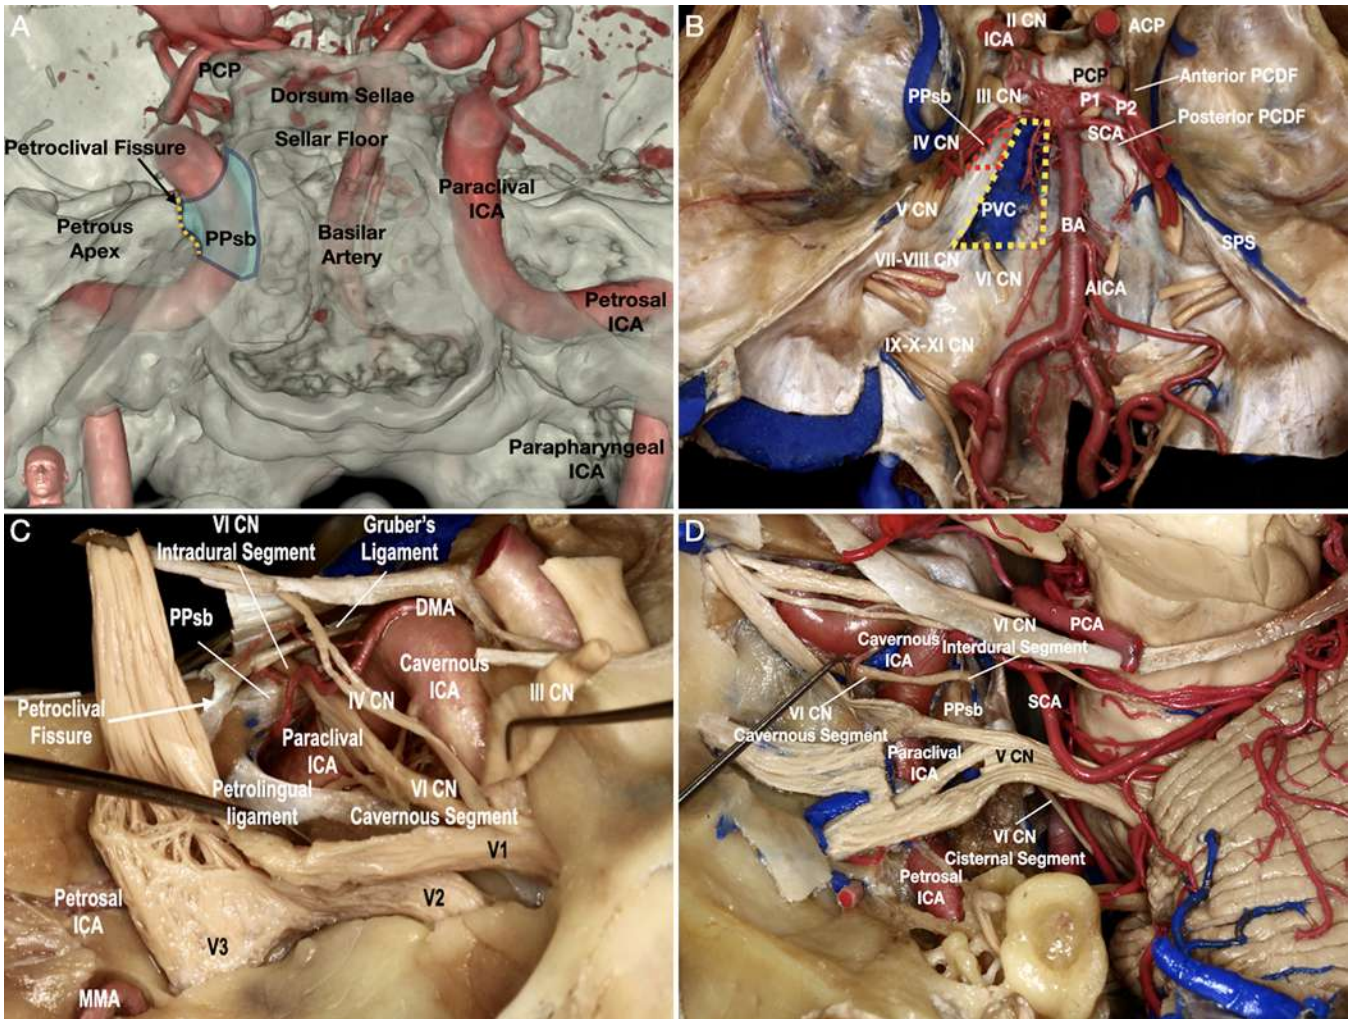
Neurovascular relationships. A: Anteroposterior view of a skull base CT angiography reconstruction. The petrosal process of the sphenoid bone (PPsb) (blue shading) is posterior to the paraclival internal carotid artery (ICA) and demarks the transition between the extracavernous and intracavernous segments. The PCF (yellow dotted line) is lateral to the ICA. The 3D reconstruction was created from CT angiography using Surgical Theater software (Surgical Theater, LLC). B: The brain has been removed, preserving the cranial nerves (CNs) and vascular structures. The inner dural layer has been partially opened on the left side to show CN VI running inside the petroclival venous confluence (PVC) (yellow dotted trapezoid) but outside the IPS. The PPsb location is highlighted (red dotted triangle). C: Lateral view of the lateral wall of the right CS. The PPSb is shown posterior to the ICA and inferior to CN VI. The course of CN VI can be observed inside the CS. CN V is retracted inferiorly to show the PLL, which together with the PPSb forms the inferior limit of the CS. D: Overview of the course of CN VI and the carotid artery. The petrosal bone has been drilled to show the prepontine cistern and the cisternal segment of CN VI, as well as the petrosal segment of the ICA. The PPSb marks the transition between the interdural and cavernous segments of CN VI and the transition between the paraclival and the cavernous ICA. ACP = anterior clinoid process; AICA = anterior inferior cerebellar artery; BA = basilar artery; DMA = dorsal meningeal artery; MMA = middle meningeal artery; P1 = p1 segment of the posterior cerebral artery; P2 = p2 segment of the posterior cerebral artery; PCDF = petroclival dural fold; PCP = posterior clinoid process; SCA = superior cerebellar artery; SPS = superior petrosal sinus; V1 = first branch of the trigeminal nerve; V2 = second branch of the trigeminal nerve; V3 = third branch of the trigeminal nerve. With permission from Juan C. Fernandez-Miranda and *The Neurosurgical Atlas* by Aaron A. Cohen-Gadol. Figure is available in color online only.
